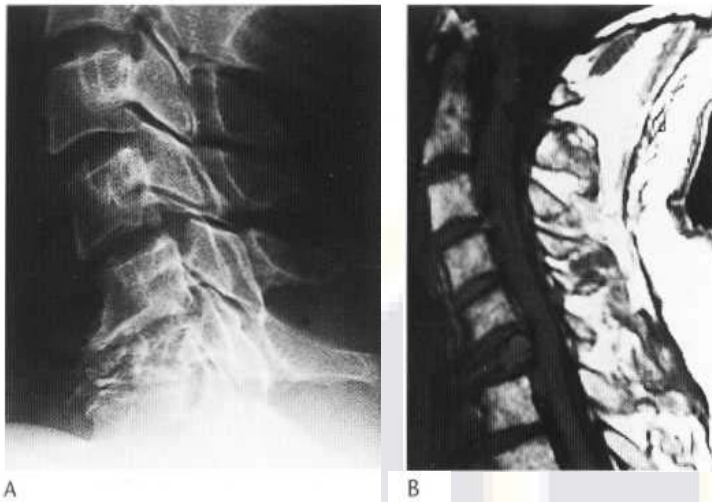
Plasmacytoma. (A) Conventional cervical spine radiograph showing osteolytic destruction of C6 with pathological collapse of the vertebral body. (B) Sagittal T_1 -weighted MR image showing the intermediate-signal-intensity lesion of C6 resulting in focal extradural compression of the spinal cord.
